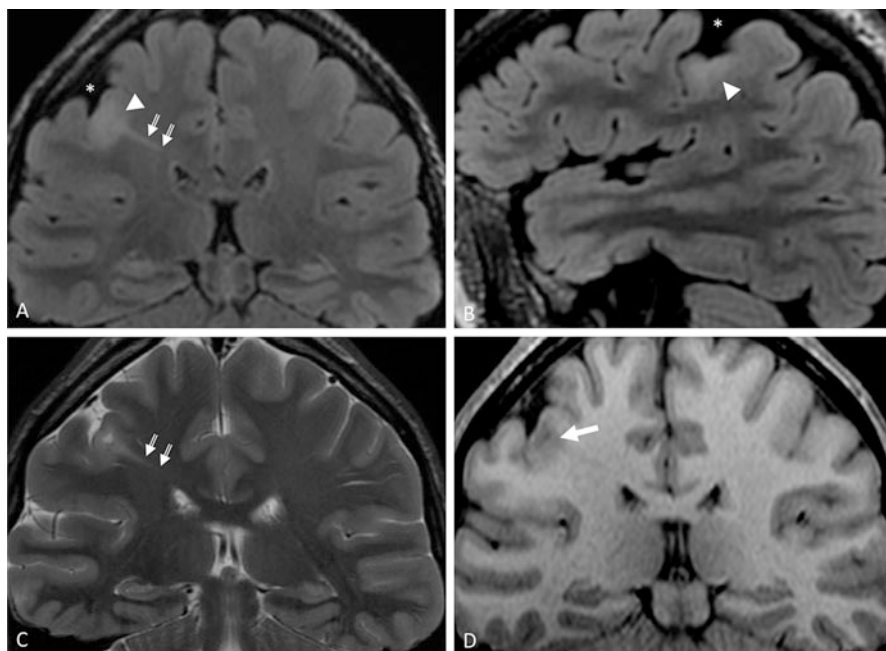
Coronal and axial reformats of a 3D FLAIR (a, b), coronal T2 (c), and T1 (d) in a patient with right frontal lobe epilepsy show the typical pattern of a FCD: Cortical thickening and blurring (arrow), cortical and subcortical hypersignal (arrow head) tapering to the ventricle wall (“transmantle sign” – double arrow), and sulcal abnormality with enlarged sulcus (asterisk)
